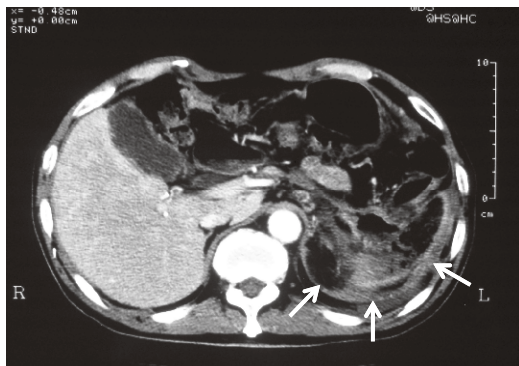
One month later, CE-CT showed almost complete disruption of the splenic parenchyma (arrows).
